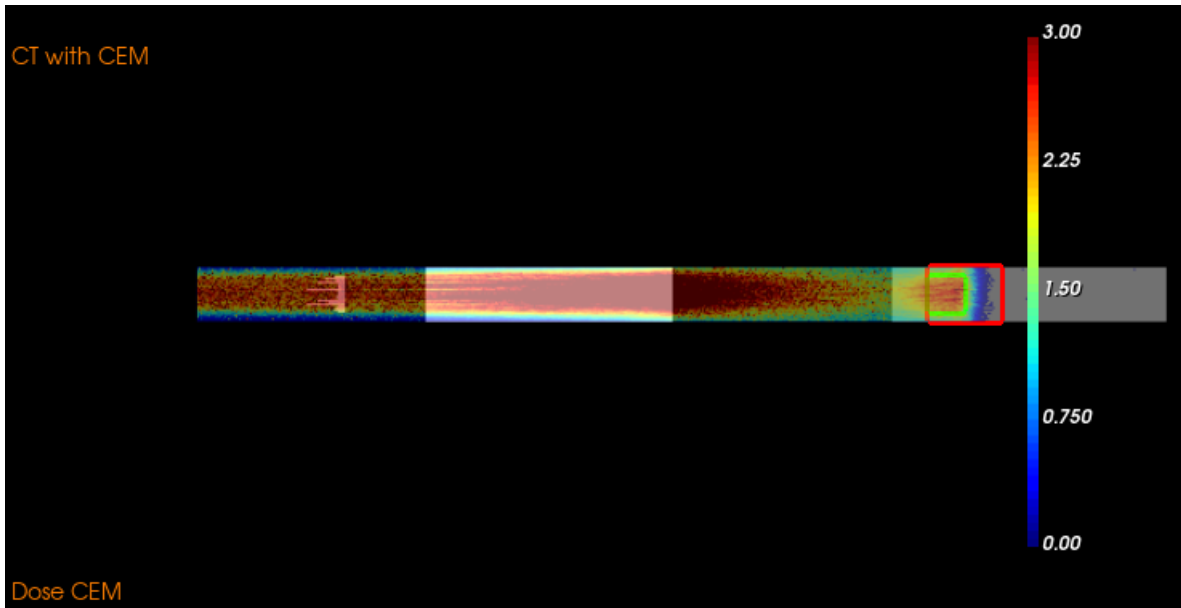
Example of a lateral view of a CT with CEM, range shifter, water tank, and dose map. The color map represents the dose in Gy
